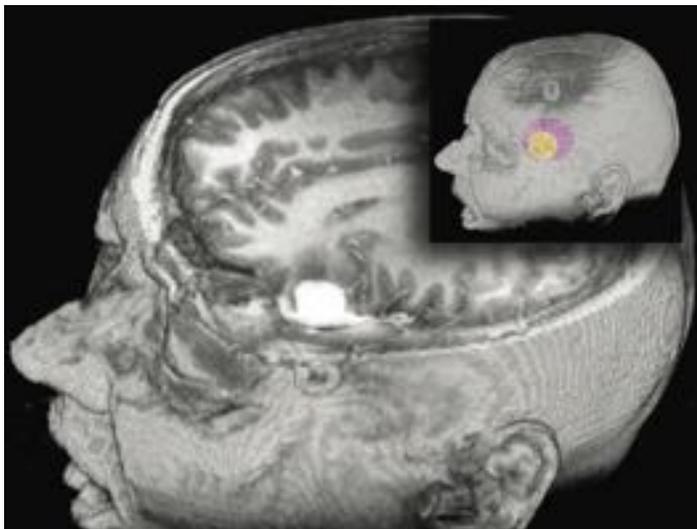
Preoperative craniotomy placement. The figure shows a three-dimensional reconstruction from surgical planning T1-weighted, gadolinium-enhanced images. The relationship of the meningioma and its dural tail to a surface fiducial is demonstrated. (Inset) A limited craniotomy (yellow) and an extended craniotomy, to include the dural tail, are demonstrated on a surface reconstruction.
